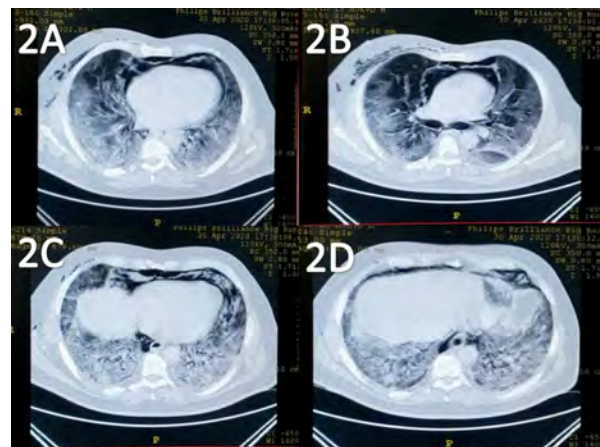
Chest CT features. Axial pulmonary window obtained without intravenous contrast. Panel 2A,2B showed air dissect from the hilum, and the pericardial pleura Panel 2C, 2D showed bilateral pulmonary parenchyma with ground-glass opacities.
